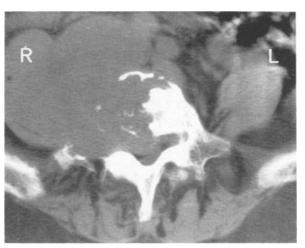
Computed tomography showing a large retroperitoneal cellular schwannoma with advanced destruction of the body of the 5th lumbar vertebra, in a 71-year old woman. The tumour, which had initially been asymptomatic, had been discovered at a routine gynecologic check-up three years earlier. The initial computed tomography led to the suspicion of a schwannoma, and the patient underwent repeated computed tomographies, which showed a slow tumour growth and slow yet progressive vertebral destruction. Due to the development of neurologic symptoms and the subsequent advanced vertebral destruction, the patient underwent surgery and the multilobulated tumour, 8 cm in diameter, apparently originating from an adjacent spinal nerve, was enucleated. Apart from a slight decrease in sensation in the right leg, the patient is currently in good health, 18 months postoperatively
